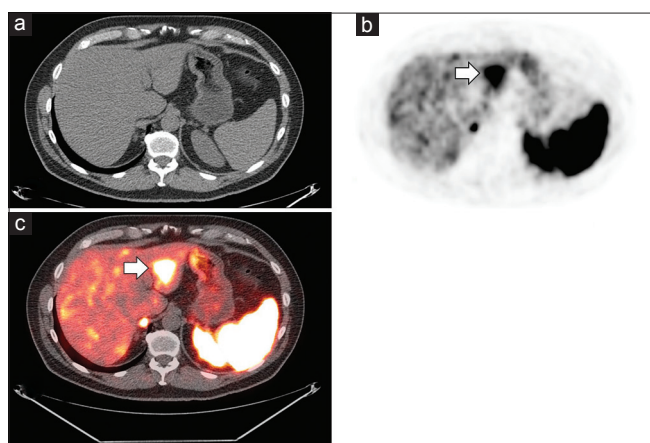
Axial views of the computed tomography (a), positron emission tomography (b), and positron emission tomography/computed tomography fusion (c) demonstrating the largest liver metastasis (arrows) with a maximum standard uptake value of 23.9
